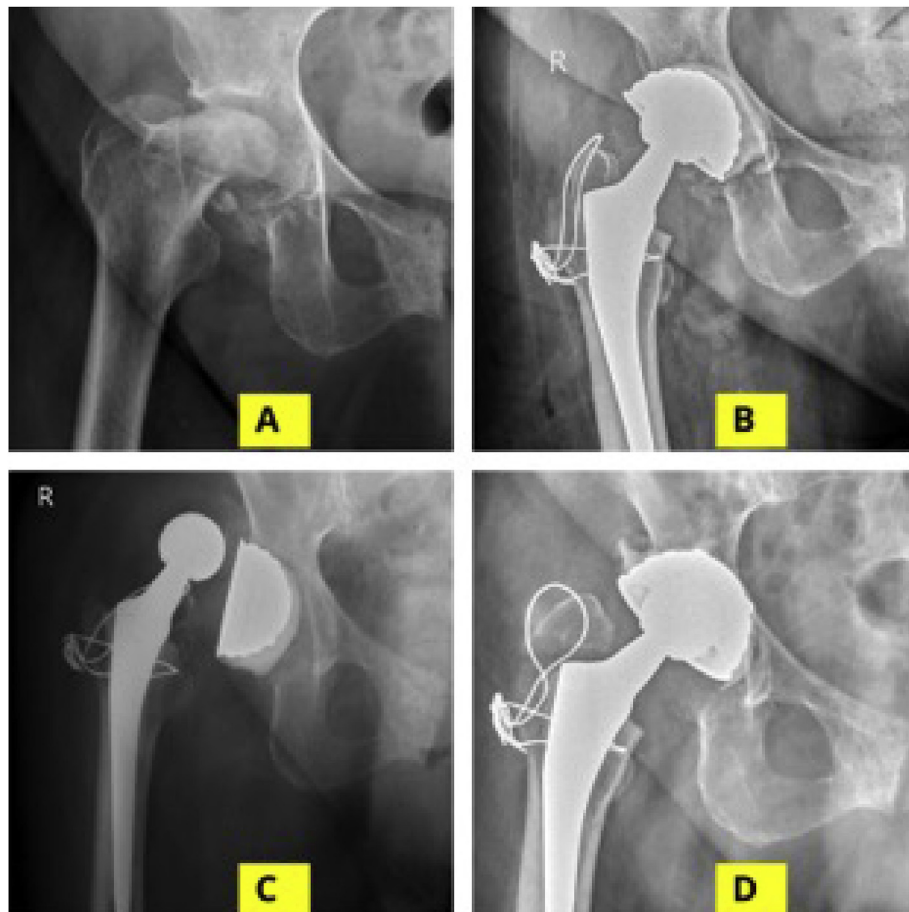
(A) Anteroposterior radiograph of 88 years female showing Right hip AVN with secondary arthritis with collapsed head; (B) Immediate postoperative radiograph showing Right hip dual mobility cemented THR; (C) Loosening and failure of cemented acetabular cup 2 months after surgery; (D) Revision with cemented dual mobility acetabular cup with retention of femoral stem was performed.
